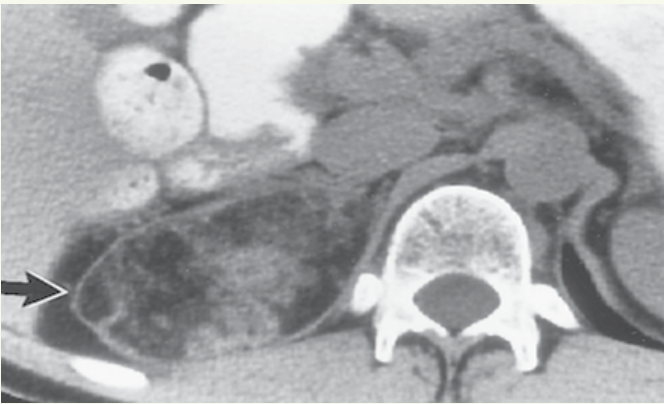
A CT scan showing a cross section of the abdomen with an arrow pointing to an angiomyolipoma (AML). When these were measured in patients before and after taking Rapamycin there was a 26% reduction in size after a year.
